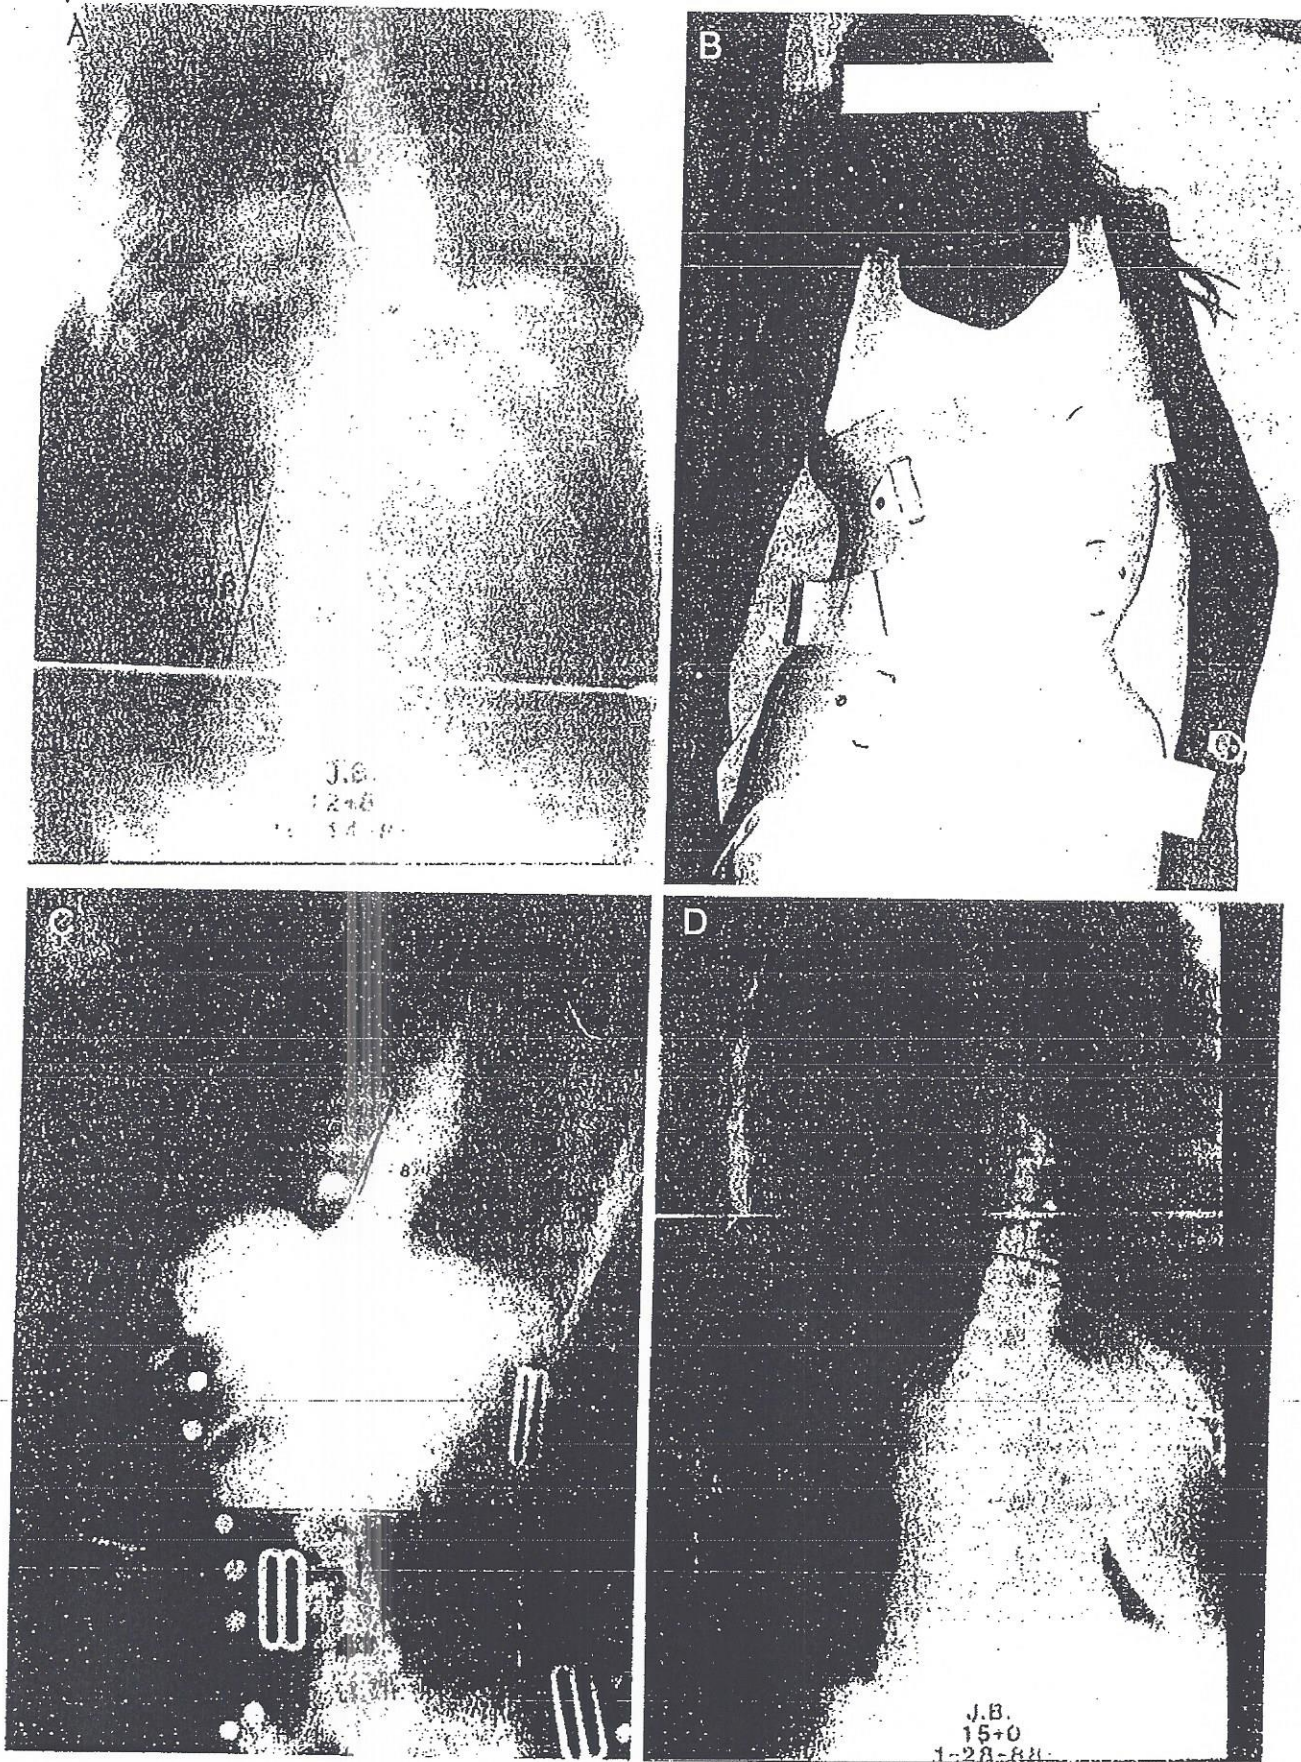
A. A 12-year, 8-month-old girl with 34° right thoracic scoliosis, which had progressed from 27° during 4 months of observation. B. Initial encephalograph. C. Initial x-ray in Charleston bending brace. D. Scoliosis measures 37° 6 months after completion of brace treatment.
